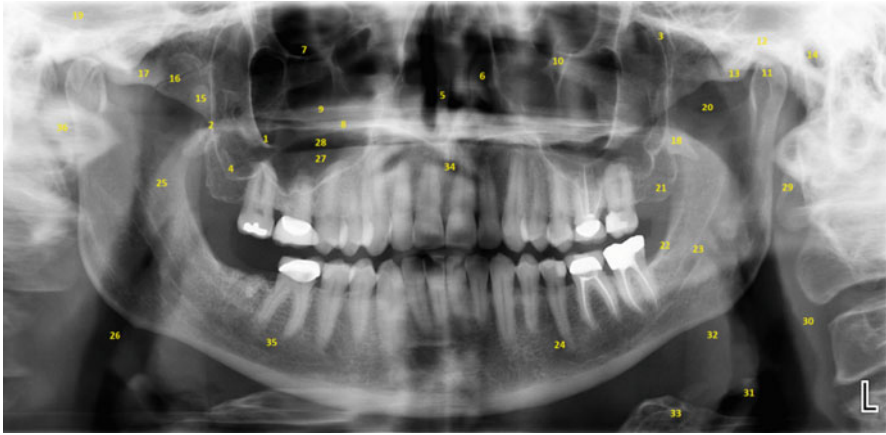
Panoramic radiograph showing normal anatomical structures. Use the numbers in the radiograph to correspond to the key
